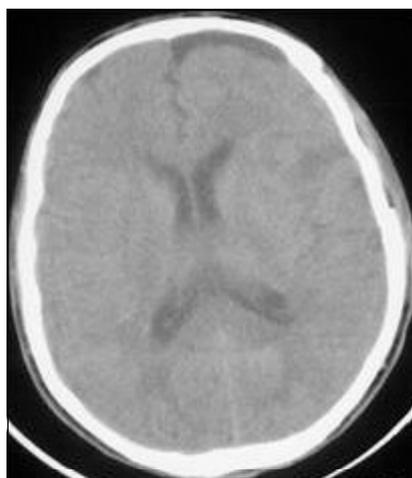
Follow-up CT at the 3rd post-operative month with no space occupying lesion and no pathological densities.
